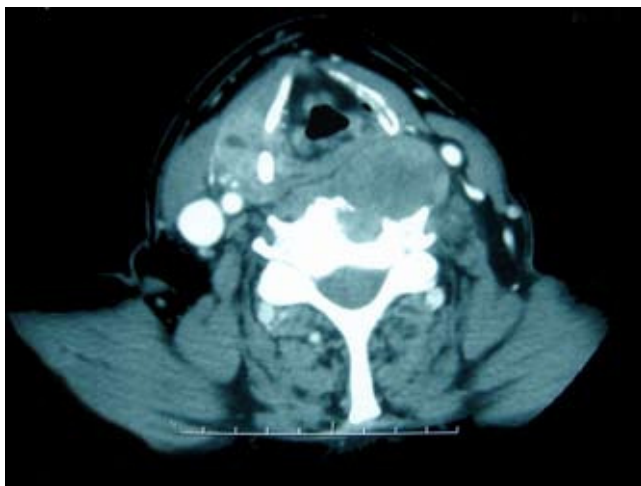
Cervical CT. Prevertebral lesion, isodense, eroding the vertebral body and bulging into the posterior hypopharynx wall.
